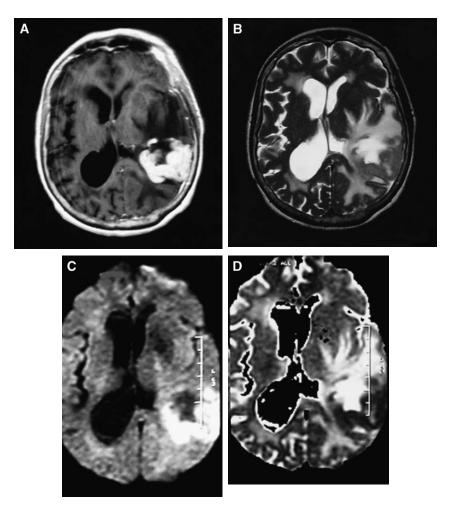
A 75-year-old woman with a glioblastoma multiforme. (A) Contrast-enhanced, axial, T1-weighted image shows an enhancing necrotic mass surrounded by an abnormal hyperintense area on the axial T2-weighted image (T2WI). (B) These abnormal hyperintense T2WI areas can represent peritumoral edema or infiltrating tumor. The tumor is isohypointense on the T2WI, indicating high cellularity; this is also demonstrated as restricted diffusion on the diffusion-weighted image (C) and apparent diffusion coefficient map (D).
